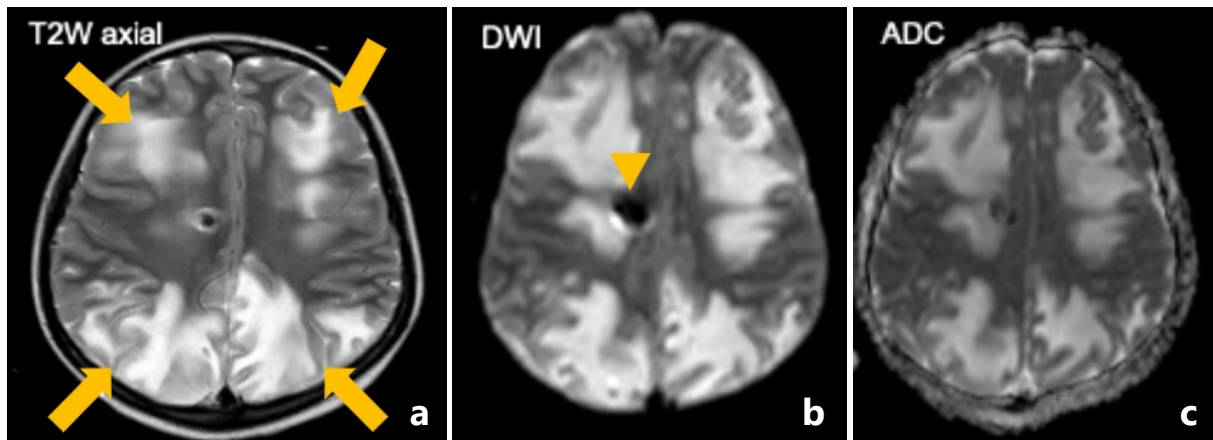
Non-enhanced MRI brain of a 13-year-old patient on induction chemotherapy for acute lymphoblastic leukaemia, presenting with seizures and labile hypertension [6]. (a) The T2 sequence shows bilateral symmetrical parenchymal abnormalities (arrows) with DWI (b) and ADC sequences (c) showing vasogenic oedema. These findings are consistent with PRES. An extra-ventricular drainage catheter was inserted for monitoring of intracranial pressure (arrowhead).
